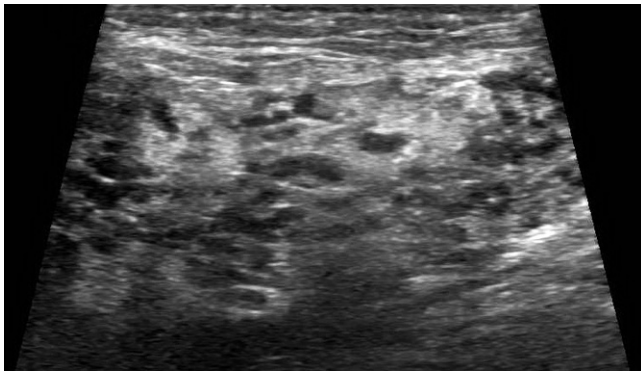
The longitudinal gray scale sonogram of the right submandibular gland contains multiple small hypoechoic nodules scattered diffusely throughout the gland.
